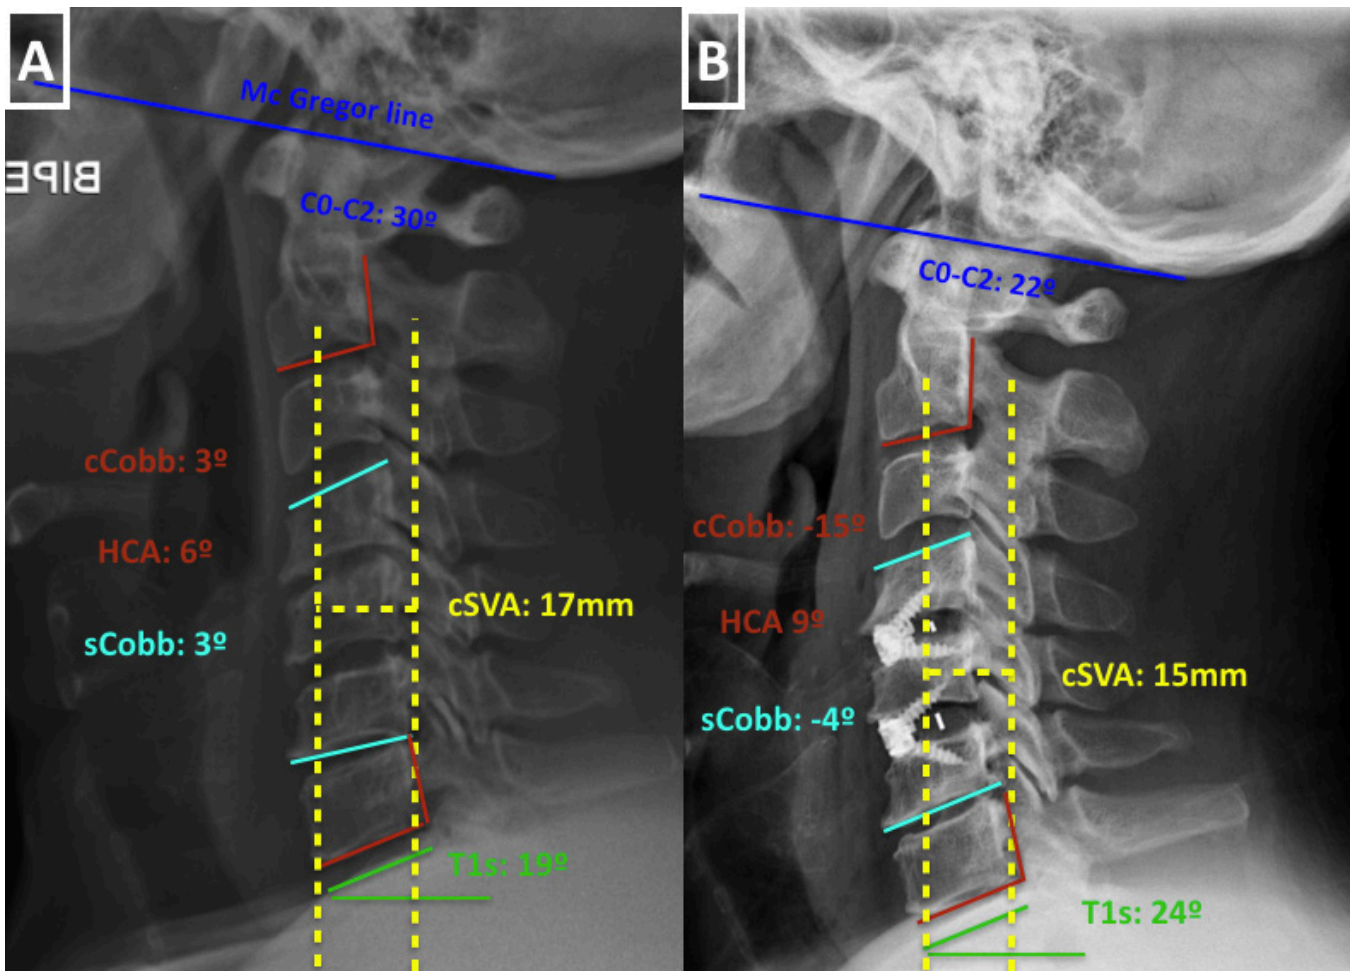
(A) Preoperative and (B) postoperative lateral x-ray images of a patient surgically treated with self-locking stand-alone anterior cervical discectomy and fusion technique for cervical spine degenerative disease. The cervical regional sagittal balance parameters measured for the present study are shown: cCobb, C2-C7 Cobb's angle; HCA, C2-C7 angle measured with the Harrison's method; sCobb, cervical segmental Cobb angle; cSVA, C2-C7 sagittal vertical axis; T1s, T1 slope; C0-C2, C0-C2 angle. HCA, Harrison cervical angle; cSVA, cervical sagittal vertical axis.
